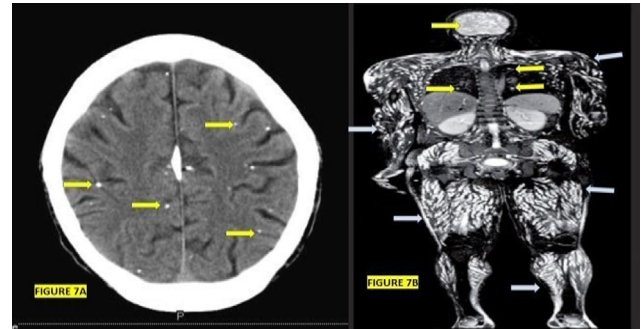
(A) An axial view of a brain CT scan shows bilateral intraparenchymal rounded calcifications (Yellow arrows) measuring between 1 mm and 10 mm with partial calcification of the falx cerebri; (B) Whole body CT scan: Shows tubular-shaped multiple muscular calcifications (Light blue arrows) plus calcifications on the tongue, orbit, heart, lungs, face, pancreas, thyroid, parotid, liver, spleen, kidney, psoas muscle, pharyngeal, and mesenteric lymph node. No calcified cysticercosis in the adrenal glands was observed
